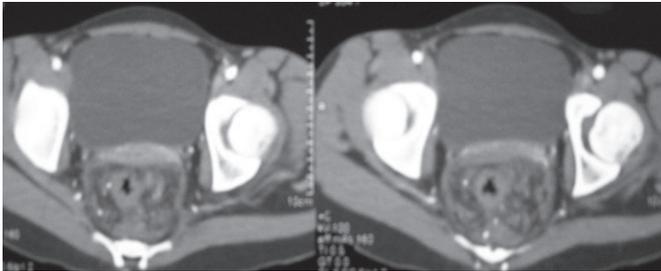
CT angiography scan of abdomen and pelvis showing a well defined, homogenous perirectal and anorectal soft tissue mass with multiple small calcifications
